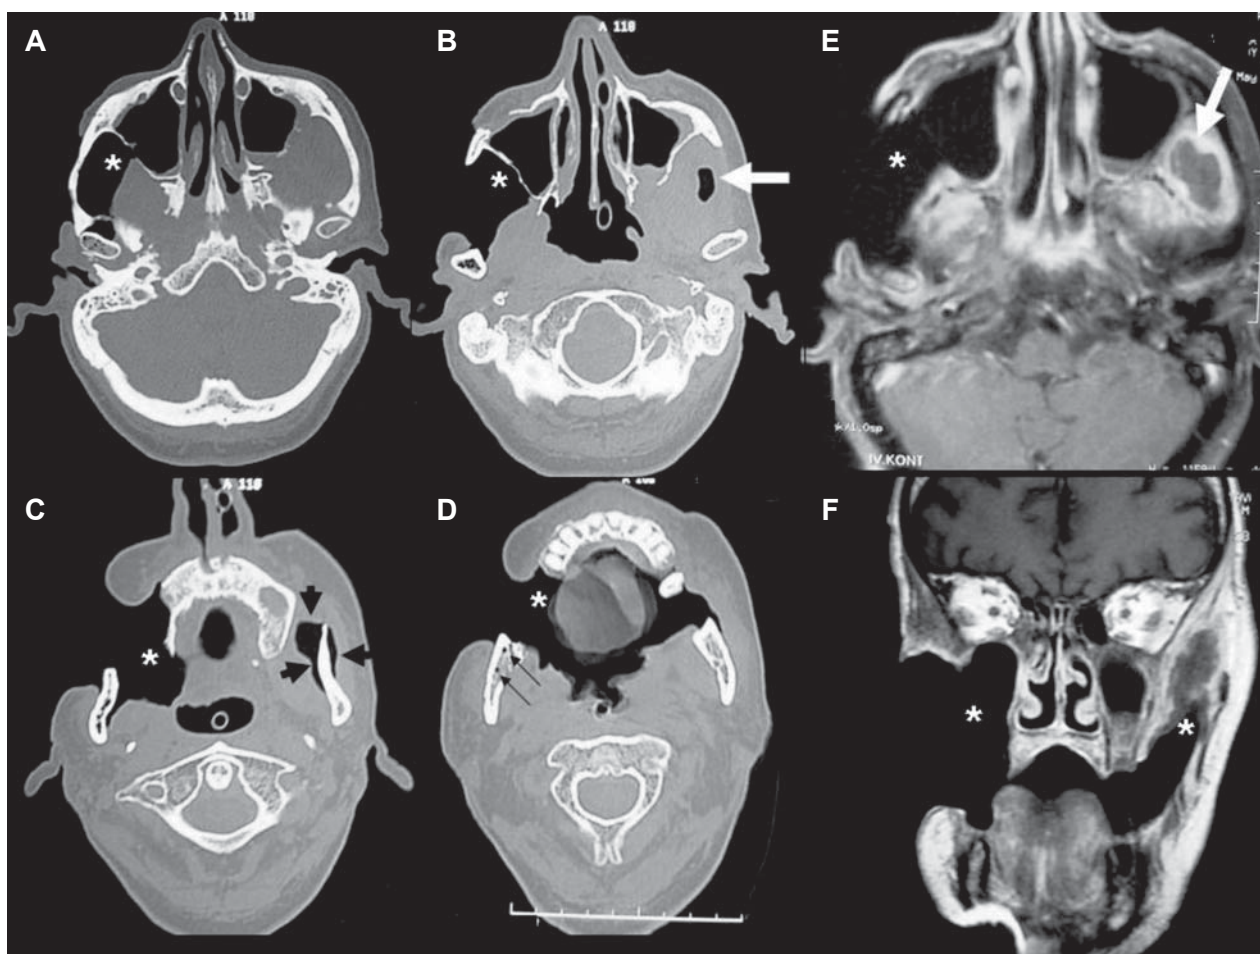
Axial CT (A-D) and contrast enhanced T1-weighted axial and coronal MRI (E, F) images: The cavity (asterisk) begins at the inferior border of the right zygoma, invades the temporal muscle and extends to the masticator space. The cavity communicates with the mouth through the erosion of the lateral wall of the maxilla. Necrosis is also present in the periodontoid soft tissue of the left mandible (black arrows). Lytic areas are seen in the anterior and lateral walls of the right maxillary sinus, posterior wall of the left maxillary sinus and the pterygopalatine plate. The right temporal part of the temporal bone has some subcortical lytic areas (thin black arrows in C). Contrast-enhanced MRI scans (E, F) demonstrates the continuum of the cavity with the oral cavity, contralateral periodontoid and temporal soft tissues. The left temporal muscle shows peripheral enhancement (white arrow).
